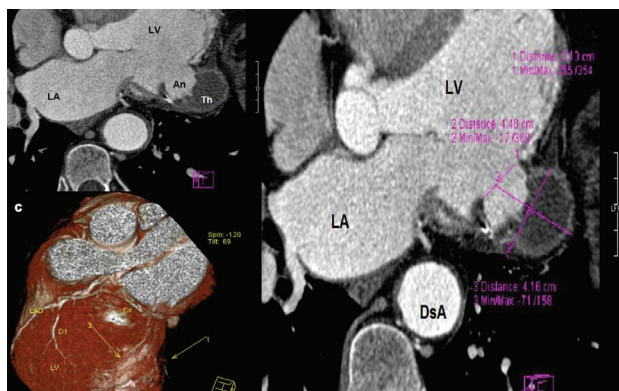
A. Contrast-enhanced axial CT image shows a pseudoaneurysm (white long arrow) surrounded by extensive intramural organized thrombus An: pseudoaneurysm; Th: thrombus; Ao: aorta; LA: Left atrium; LV: Left ventricle 1 B. the size of pseudoaneurysm is 4.48x4.16 cm and its neck is 2.13 cm in diameter 1 C. Three dimensional CT images show clearly the pseudaneurysm with outer surface calcification
